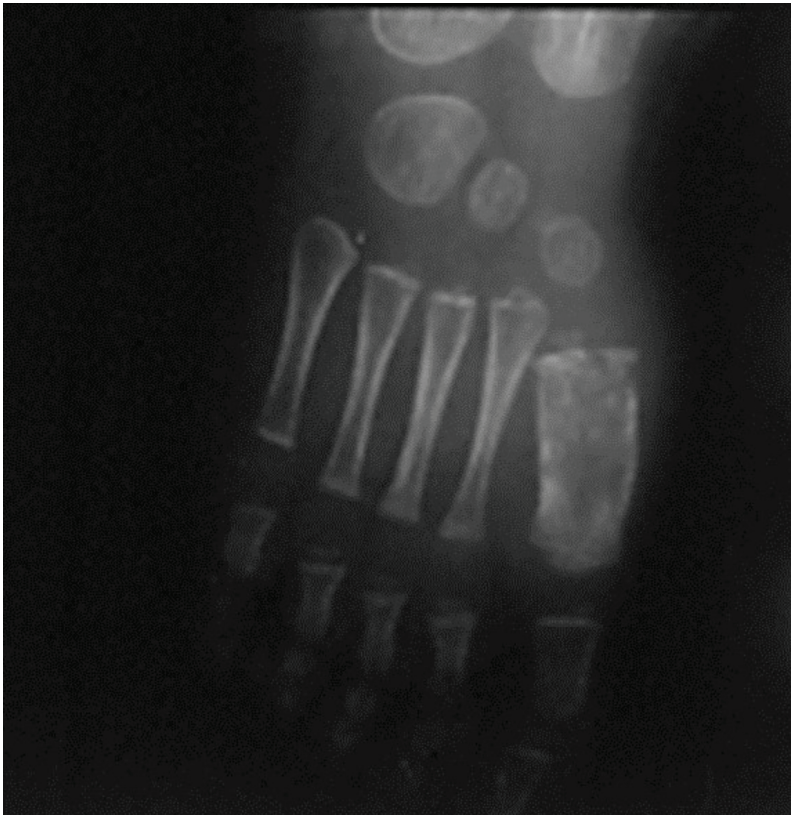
X-ray of a 2-year-old child with tuberculous dactylitis showing the diaphyseal enlargement and osteolytic lesion with blurred limits of the first metatarsal bone, demonstrating a decrease in bone density that is characteristic in this type of condition.
